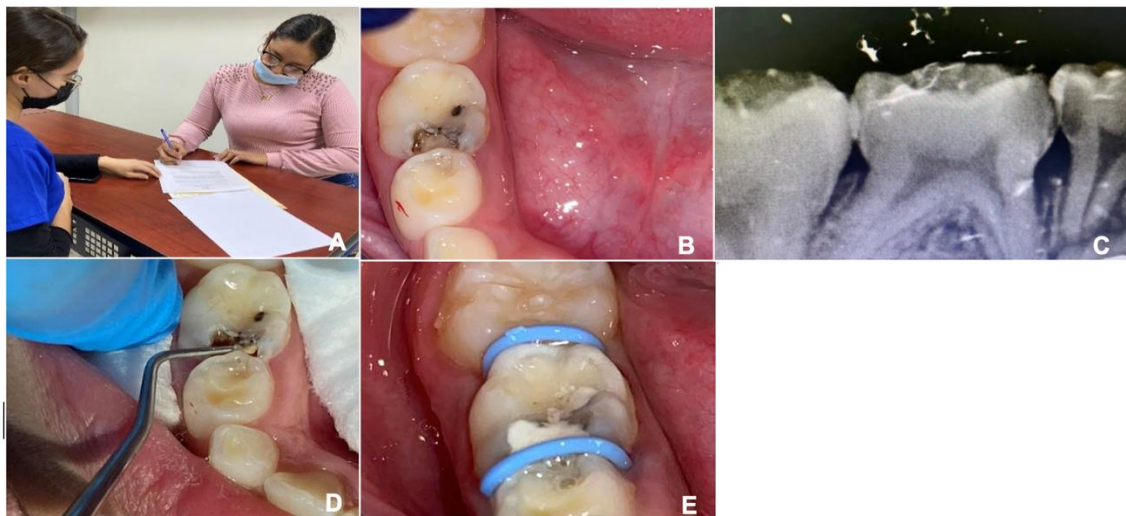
First appointment: A. Informed consent. B and C. Clinical and radiographic diagnosis. D. Cavity cleaning. E. Cavity sealing with glass ionomer and placement of separating bands.
